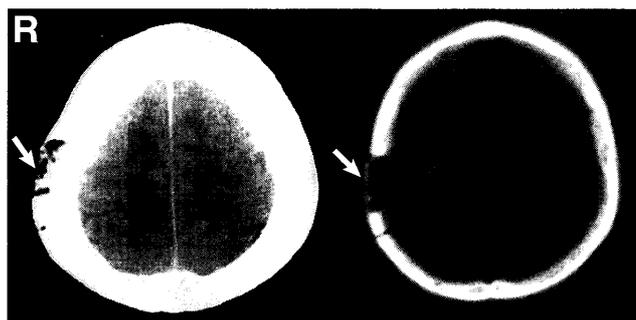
Computed tomography scans showing a defect (arrow) in the right parietal bone.
